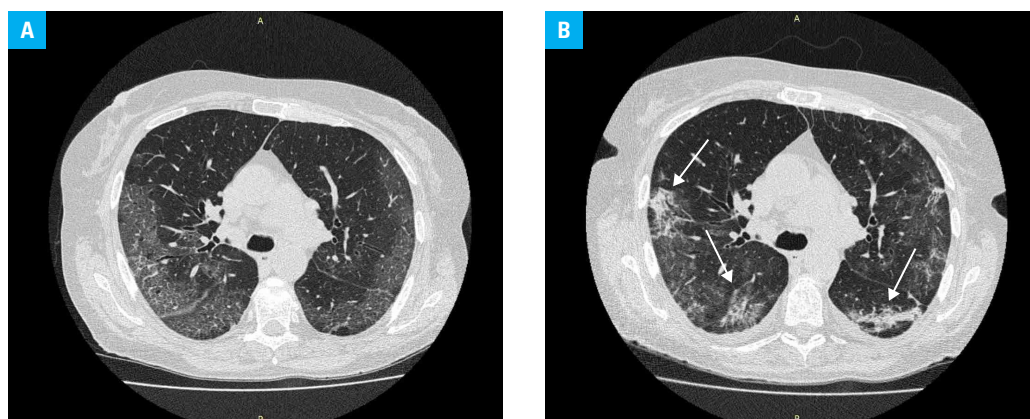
Patient 1: A – computed tomography (CT) before treatment: irregular, confluent ground-glass opacities covering all lobes in both lungs; the paving pattern in segments 2, 3, 4, and 6 of the right lung; linear compaction in the anterior middle fields and at the base of the lungs; B – CT performed 10 days after treatment with tocilizumab: extensive ground-glass opacities and consolidations in single, paving stone-like patches (arrows); the image indicates a period of sharp, highly consolidated lesions.
